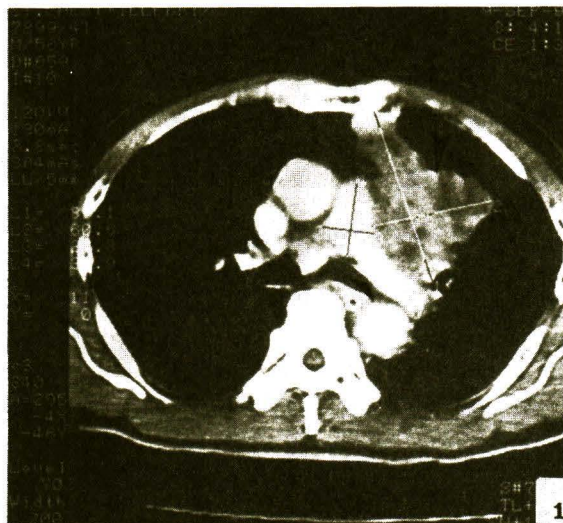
Enhanced CT chest of case 1 with bronchogenic carcinoma shows an irregular mass at the left upper lobe invading the left pulmonary trunk. (Big arrow)
